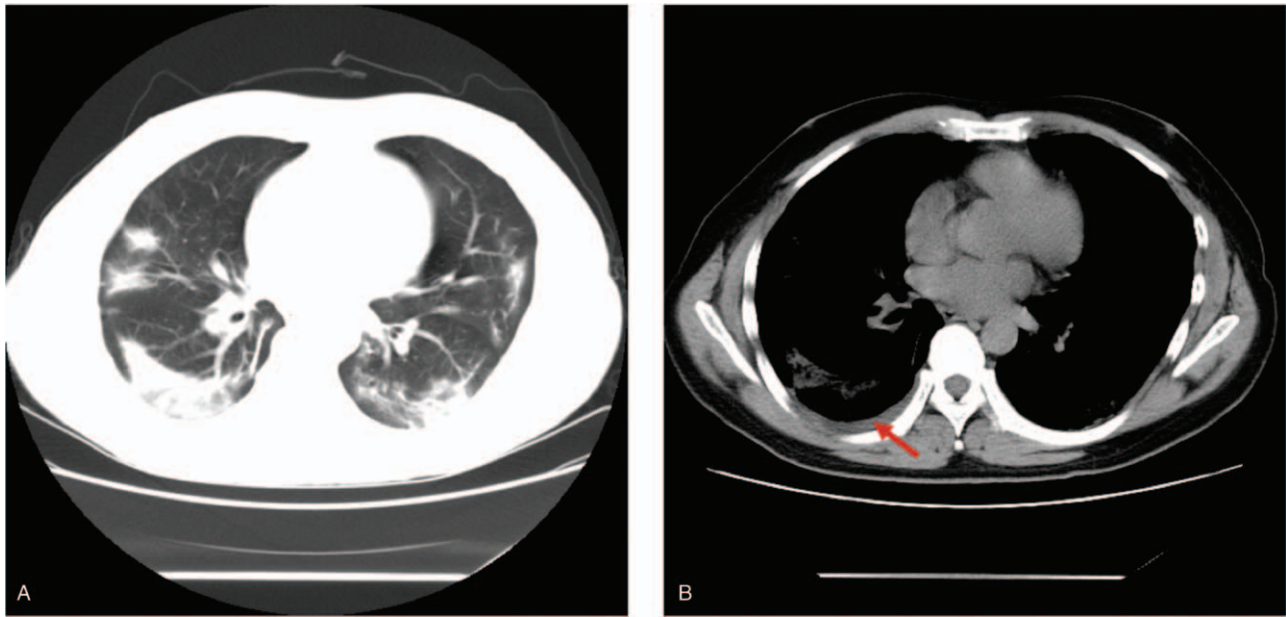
Chest CT from a 45 year-old man, showing consolidation of bilateral lungs near the pleura (A) and pleural effusion (B, arrow mark) on day 16 from symptom onset.
